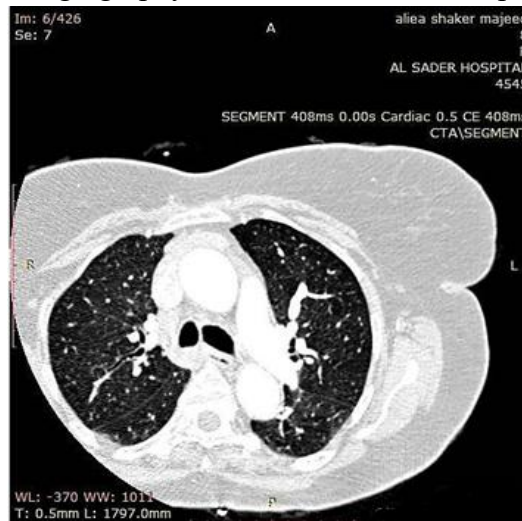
Ground glass opacification incidentally found in 45 years old woman who was referred for coronary CT angiography for evaluation of syncope, chest pain and dyspnea.
